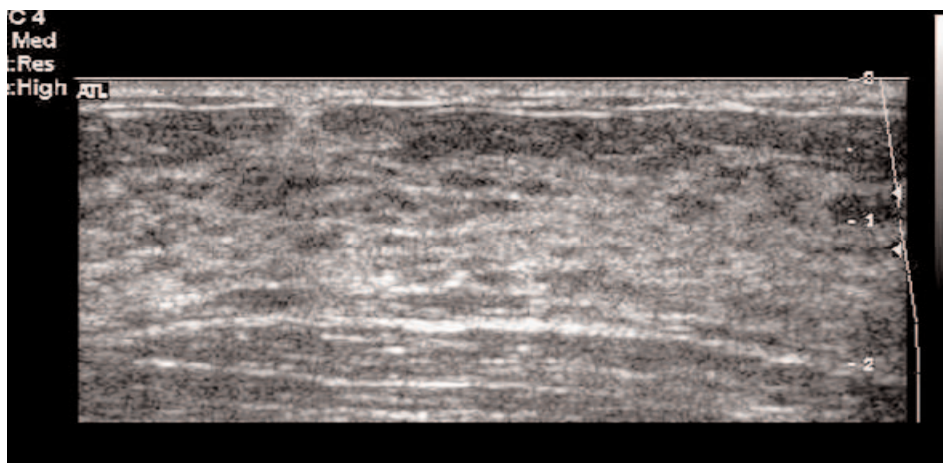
Normal sonographic anatomy: skin and subcutaneous fatty layer, mammary layer, retromammary fat.
